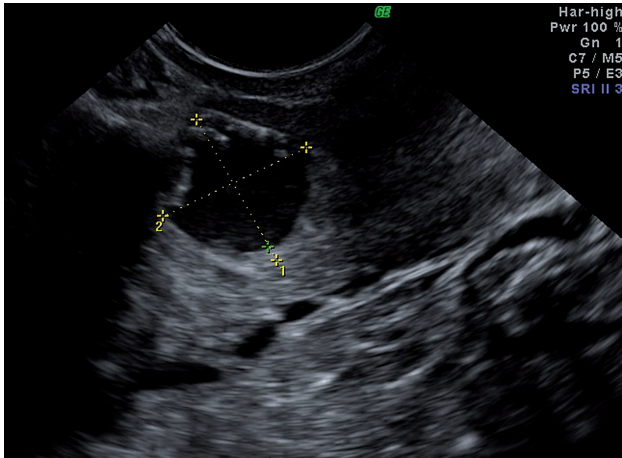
Ultrasonographic view of the cystic mass at the site of cesarean scar.
